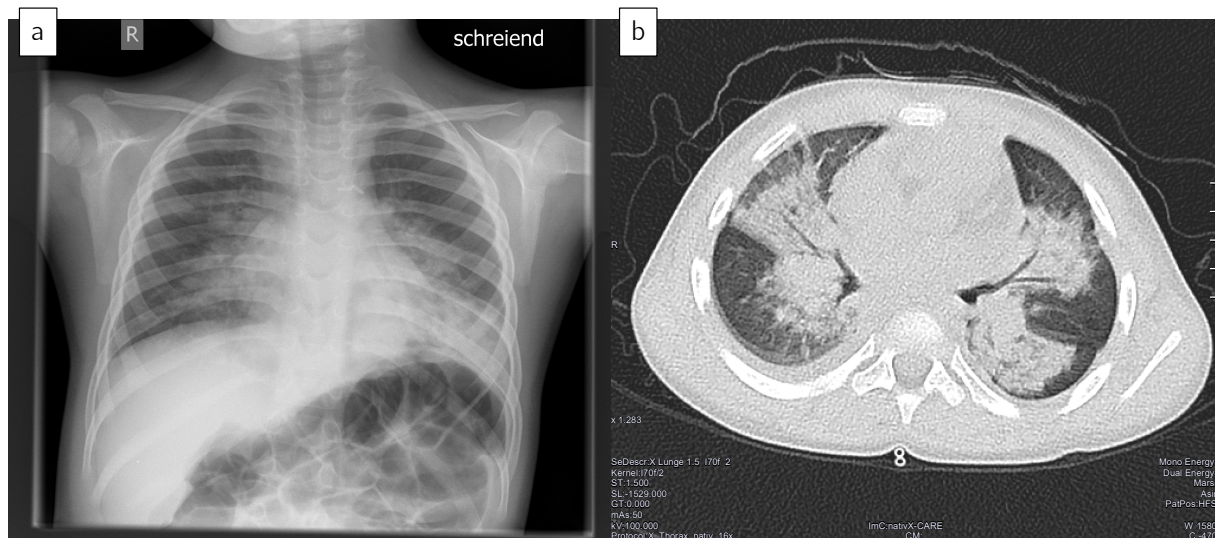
(a) chest ray posterior-anterior recorded in sitting position on day 0 of hospital admission, showing confluent infiltrates on both sides leading to bronchopneumonia with ventilation dysfunction. (b) computed tomography recorded on day 3 with features of an atypical pneumonia, with marked deterioration compared to the recording of the 0.
